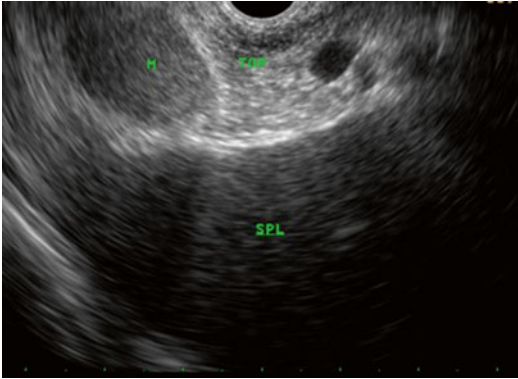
A homogeneous hypoechoic solid mass (M) with an echogenic pattern similar to the major spleen (SPL) was identified in the tail of the pancreas (TOP). Endosonographically, the accessory spleens are usually round or oval-shaped lesions with regular and sharp margins
